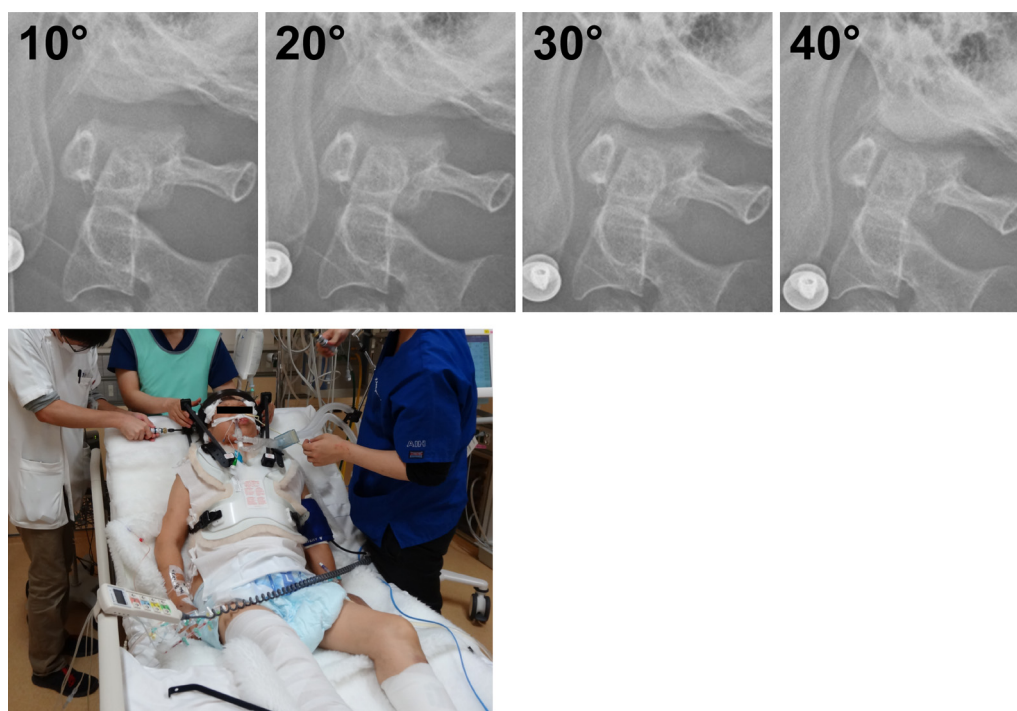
(Top) Lateral cervical spine radiography obtained during backrest elevation of 10°–40°. Condylar gap and atlantodental interval (ADI) 12 hours after halo fixation were recovered by backrest elevation in an elevation angle-dependent manner. The trend in ADI appeared inversely proportional to that of C1–C2 angulation, defined as the angle between the line parallel to the C2 end plate and the line connecting the C1 anterior and posterior arches. (Bottom) Photograph of backrest elevation with halo fixation. Note that hip and lower legs are mildly immobilized on the bed, and only the halo fixator and head are allowed to migrate caudally in this situation, which differs from the reverse Trendelenburg position described previously (Bellabarba et al.).
